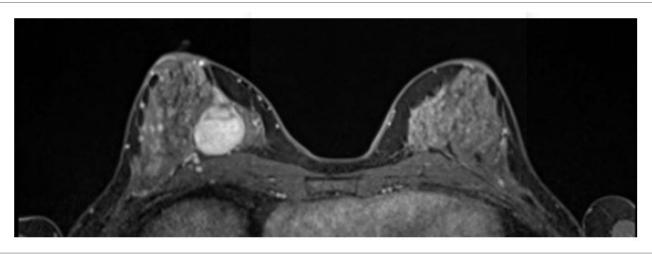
MRI showing a maligne mass in the right breast.
